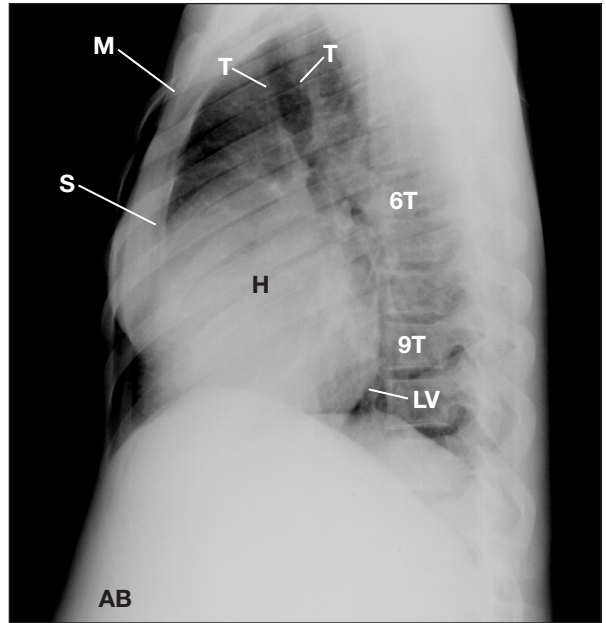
This lateral chest radiograph displays a narrow thorax; left ventricular enlargement displaced against the thoracic vertebra; and increased abdominal protuberance, reflecting ascites. Observe the depressed manubrium and body of the sternum reflecting mild pectus excavatum.
